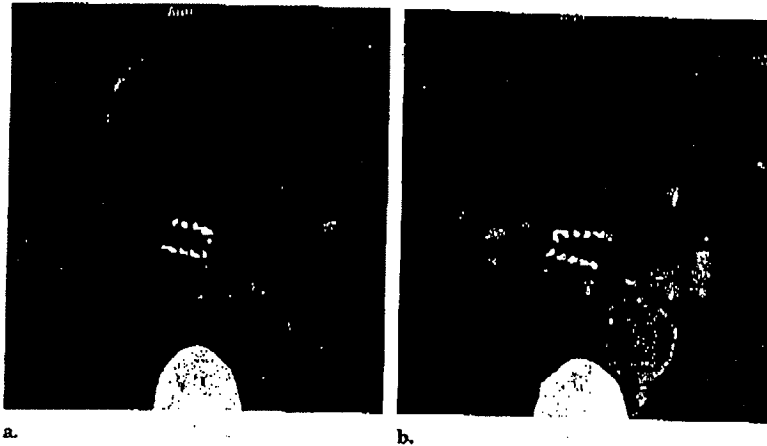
(a, b) Contiguous 8-mm CT images of patient 3 at the level of the carina. The images were acquired 1 day after placement of a 15-mm-long Palmaz stent in the left mainstem bronchus. The stent was dilated to 8 mm at the time of placement. It appears widely patent and well positioned.
